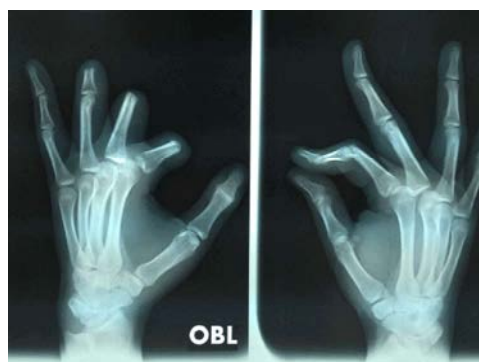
Radiographic examination done at lateral projection showing defect of the index, middle and ring finger of the left hand
